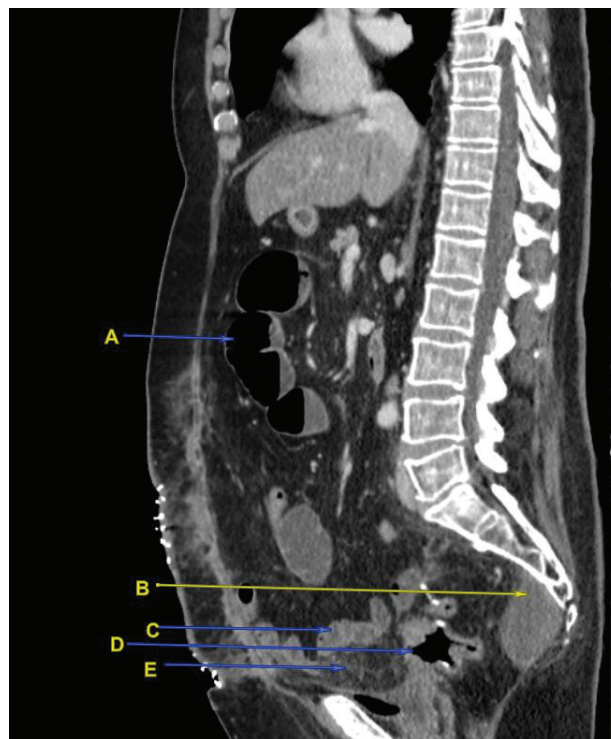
Sagittal plane and axial planes of CT scan of abdomen and pelvis on POD 9. A – distended small bowel, B – resolving pre-sacral haematoma, C – collapsed small bowel on top of omental patch (E) and D – anastomosis with no evidence of free gas or peri-anastomotic collection to suggest a leak.
